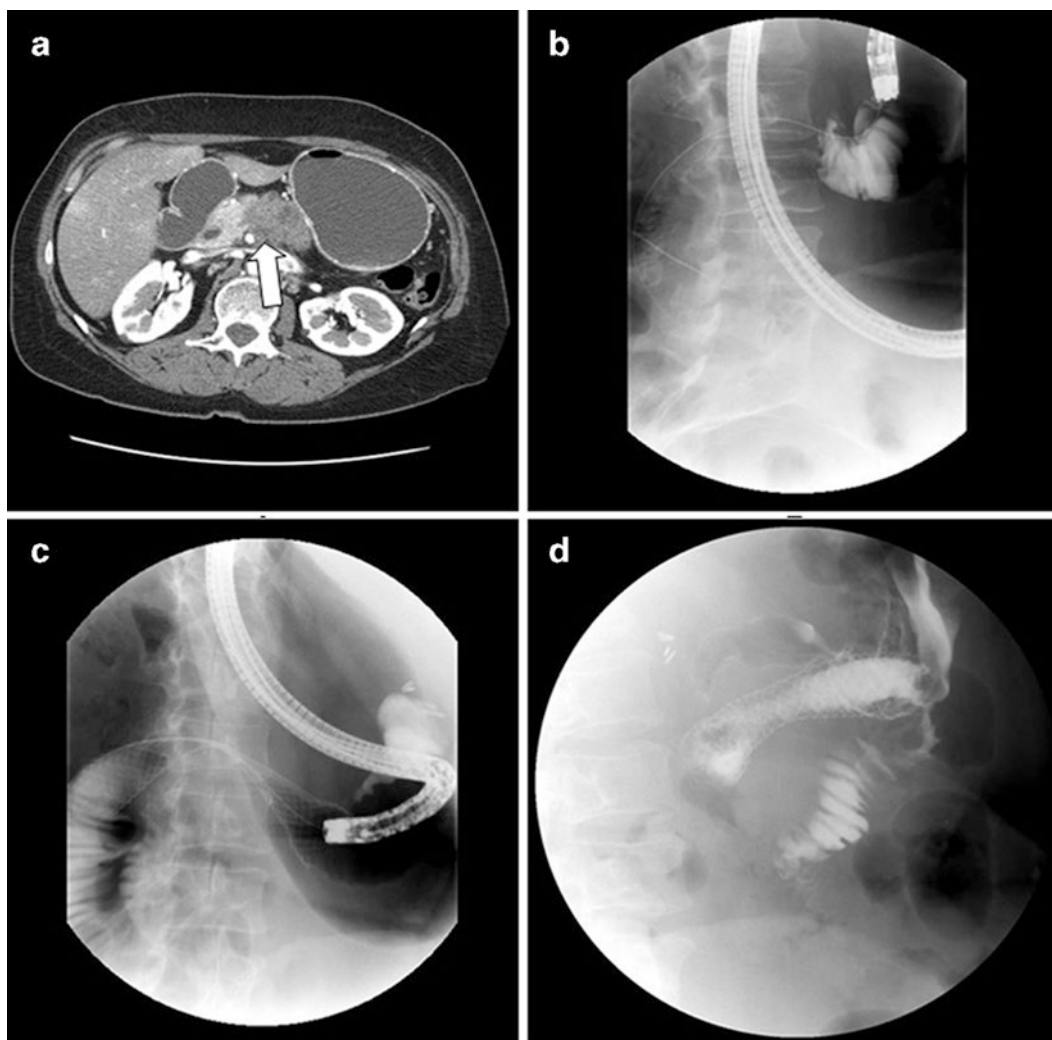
Abdominal CT scan demonstrating a markedly dilated stomach and large pancreatic mass (*arrow*) (a). Contrast was injected following which a guide wire was placed across the stenosis (b). An
